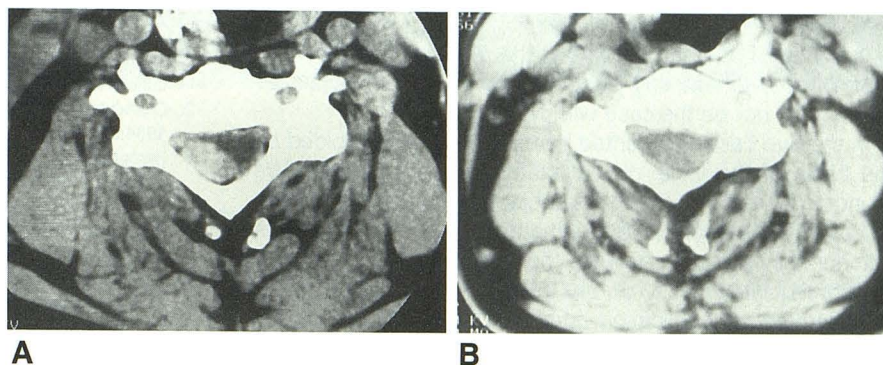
In this patient, CT was initially performed before (not shown) and after contrast material injection.
